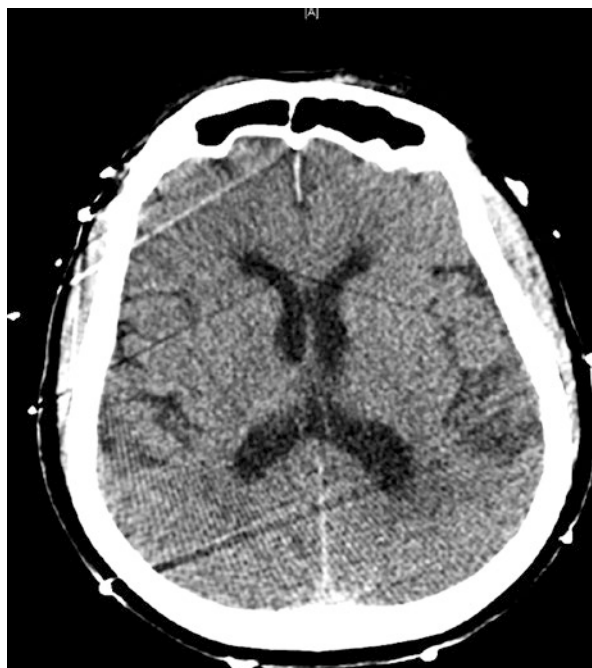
Artifact produced on head CT by standard metal electrodes
